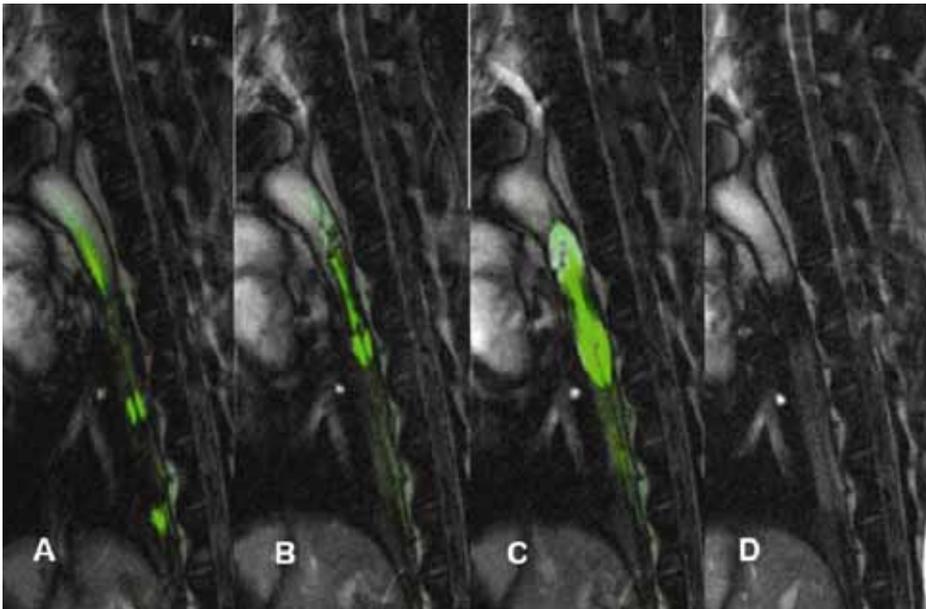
Stent delivery sequence using rtMRI. (A) Stent/balloon advancing over "active" guidewire. (B) Positioning stent within pre-determined MRI defined tissue landmarks. (C) Balloon inflation using Gd-DTPA (5mM). (D) Fully expanded CP stent in coarctation. (Note: "shielding" artifact darkens stent portion of aorta after active wire is removed.). Reprinted with permission. See end of this article.
